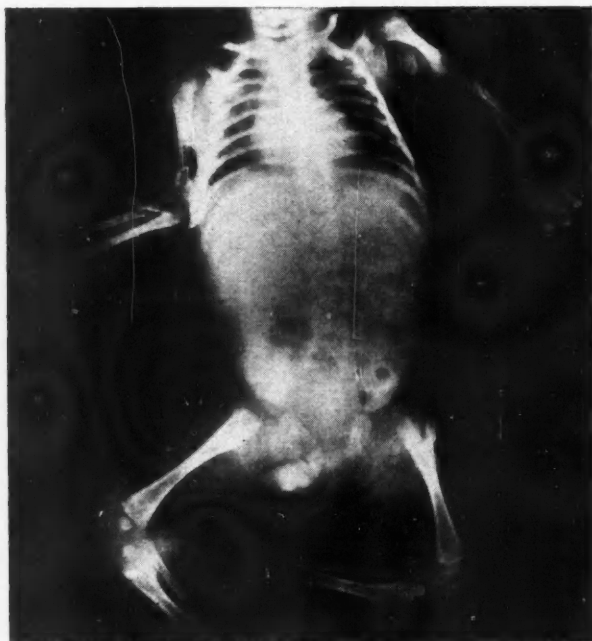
X-ray shows foci evident in the left femur, right ulna, right tibia and right femur.
